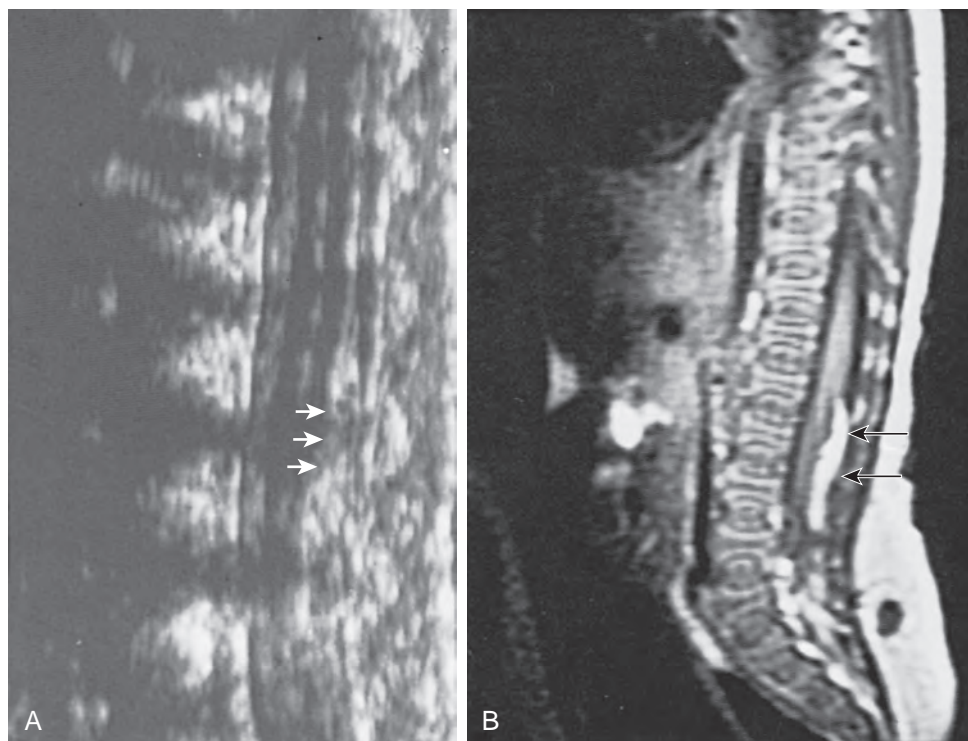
A, During the first few months of life, ultrasonography can clearly demonstrate intravertebral anatomy because the posterior arches have not completely ossified. Note that the spinal cord along with its central canal is displaced anteriorly (*white arrows*) beginning at L3 because of an intradural lipoma. B, The magnetic resonance image is juxtaposed to confirm the ultrasound findings. The longitudinal white intraspinal mass (*black arrows*) is the lipoma; the longitudinal gray mass is the spinal cord.
